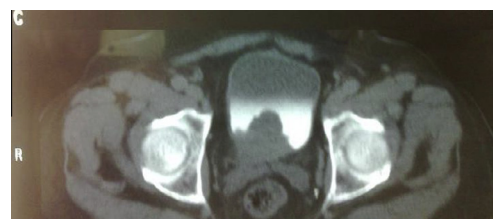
CT showing a large mass at the right lower wall of the bladder, encroaching upon the bladder neck.
